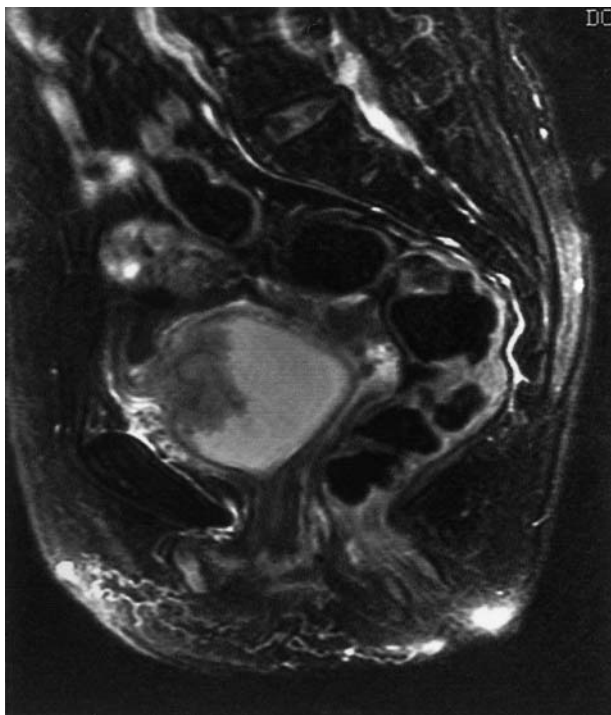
Preoperative magnetic resonance imaging (MRI) also demonstrated extravesical invasion of the tumor
